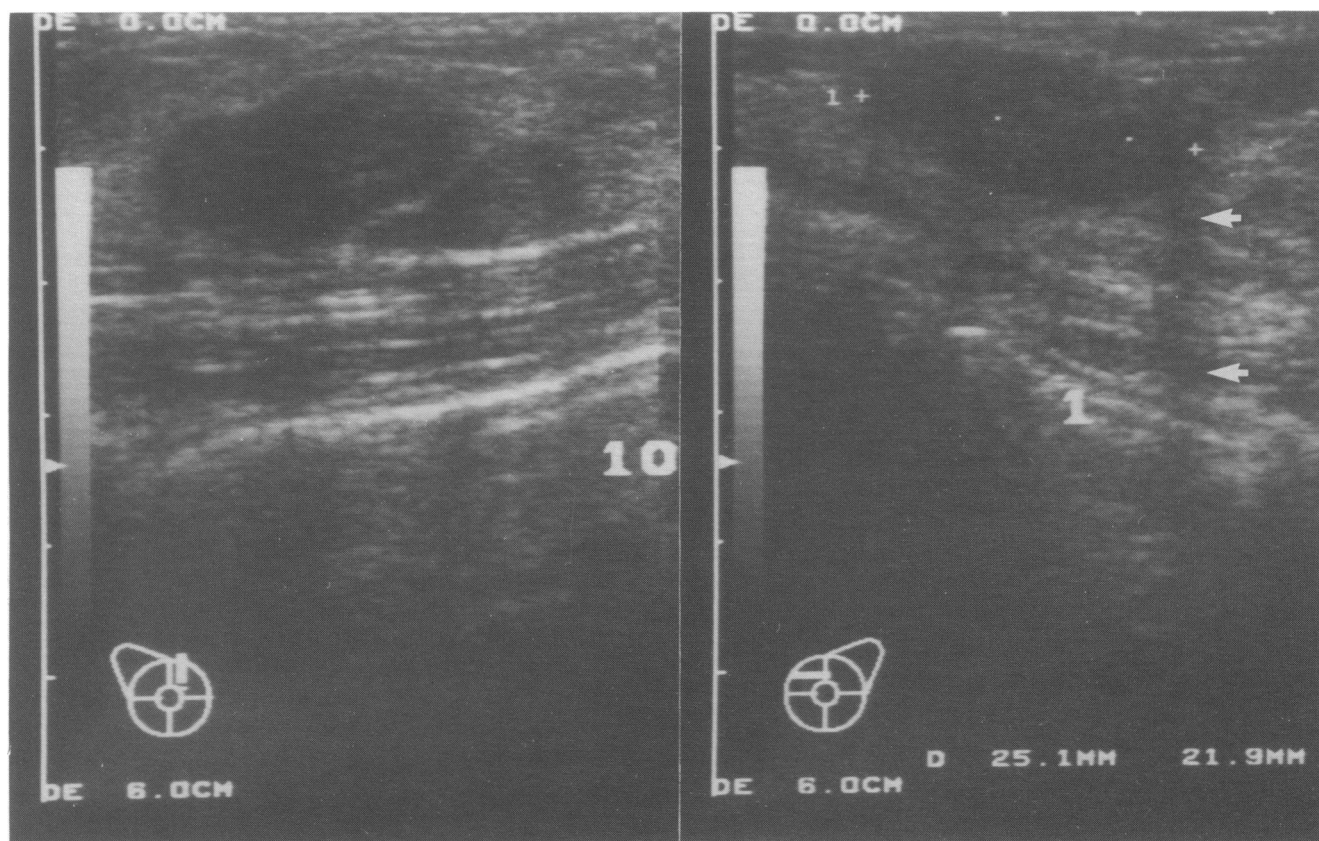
Ultrasonograms demonstrating the typical ultrasound appearances of fibroadenomas; showing two well-defined hypoechoic, homogeneous, lobulated lesions in the upper-inner quadrant of the right breast (10); and a further similar lesion in the upper-inner quadrant of the left breast (1). Attenuation from the edge of the fibroadenoma is a recognised feature (arrowed).
